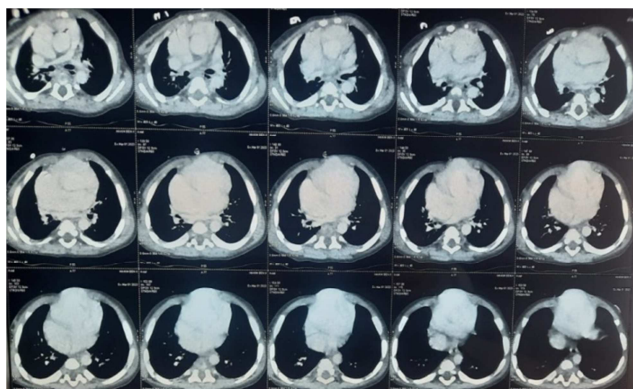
Thoraco-abdominal CT-angiography, showing the externalization of the heart.
